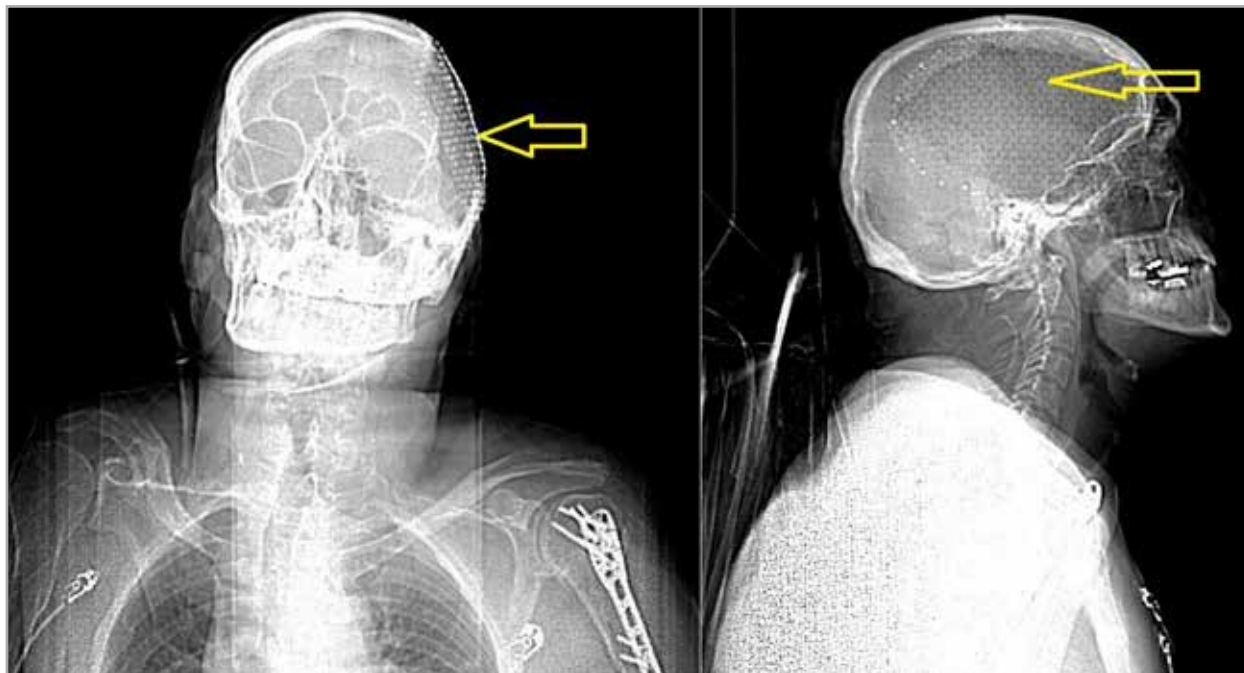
Computed tomography scan of the head showing the hardware (yellow arrow).
